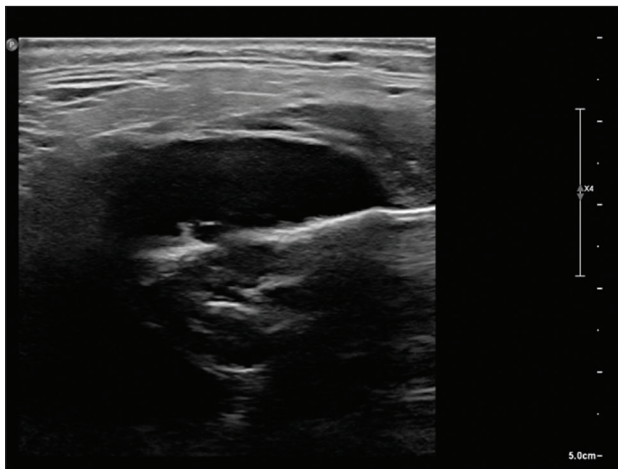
Ultrasonography revealing left parotid mass
